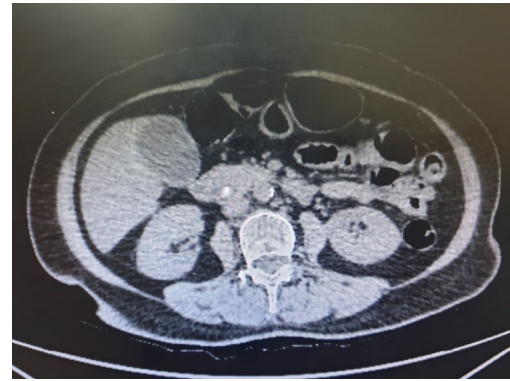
Abdominal CT scan showing a stone at distal common bile duct and hydrops of the gallbladder.
